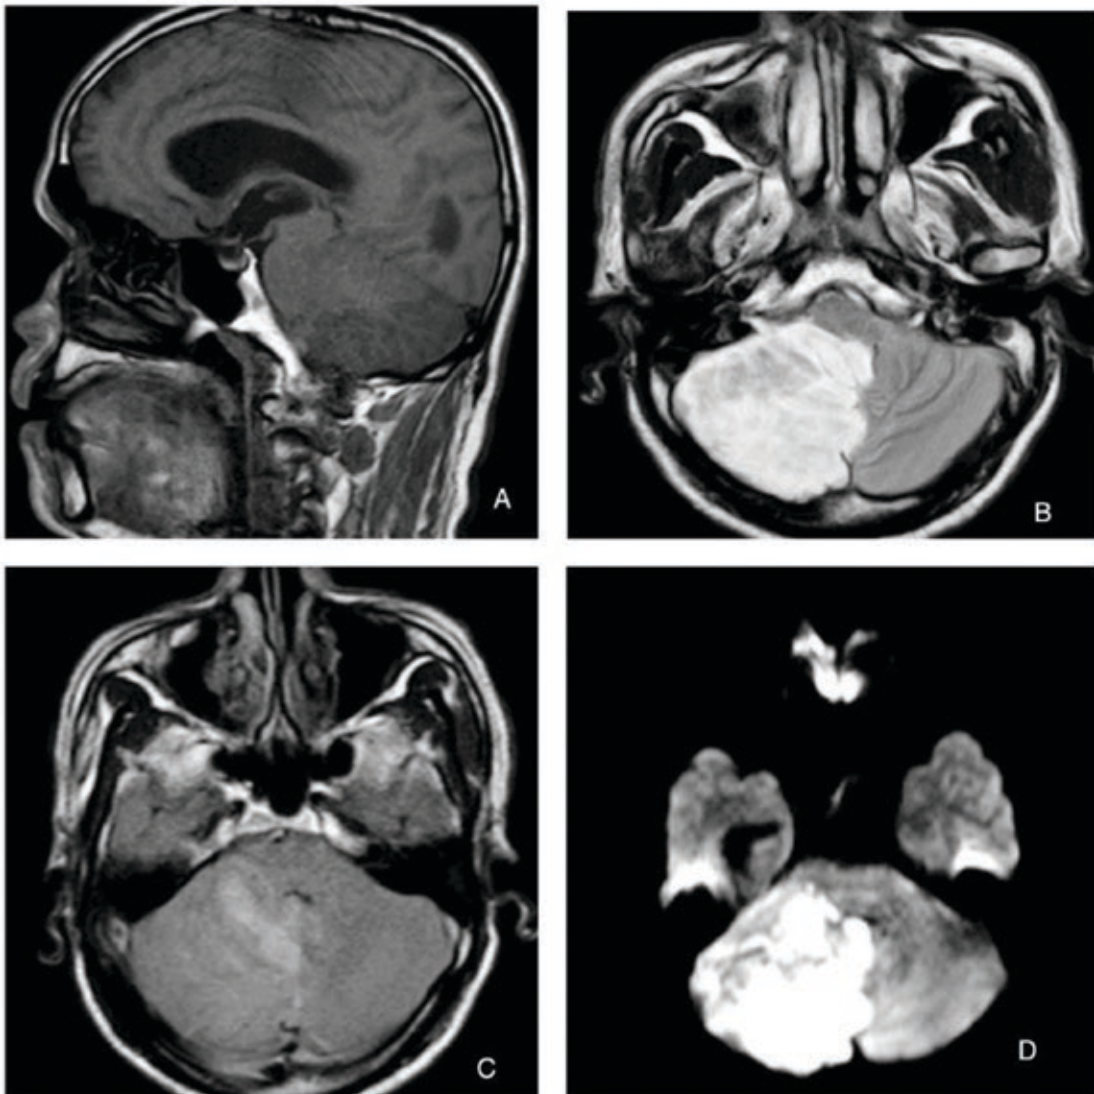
MRI brain a) T1 weighted sagittal b) T2 weighted axial image c) FLAIR axial d) diffusion-weighted showing a well-defined lesion in right cerebellum with tiger stripe appearance hypointense on T1 sequence and hyperintense on T2 sequence and bright on DWI
